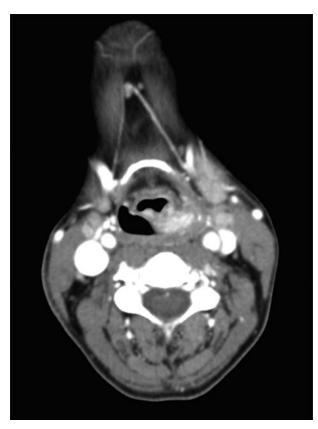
Axial computed tomography scan with contrast, showing a mass in the left tonsillar fossa approaching the left pyriform fossa.
